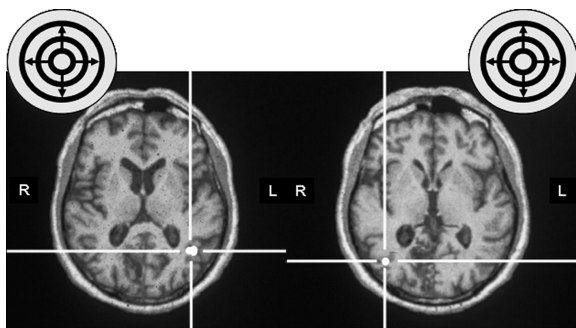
Functional magnetic resonance images of patient HK obtained 3 months after a vascular lesion destroyed his right striate cortex. A circular stimulus of expanding bright and dark rings activated the human motion complex hMT+ along with early visual cortex in the normal hemisphere when presented to the normal right hemifield. When presented to the cortically blind left hemifield, the same stimulus evoked no detectable response in early visual cortex V1/V2; nevertheless, the ipsilesional motion complex was activated.
